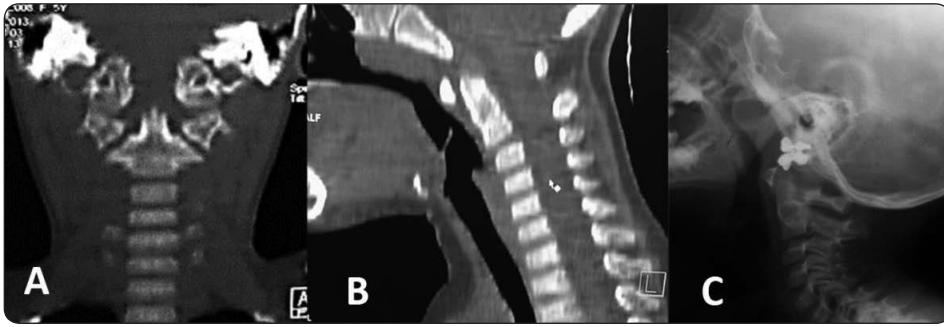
Follow up imaging after 12 weeks. (A,B) coronal and sagittal CT scan of the cervical spine showing sound fusion of the odontoid process. (C) Plain radiography showing same finding.
